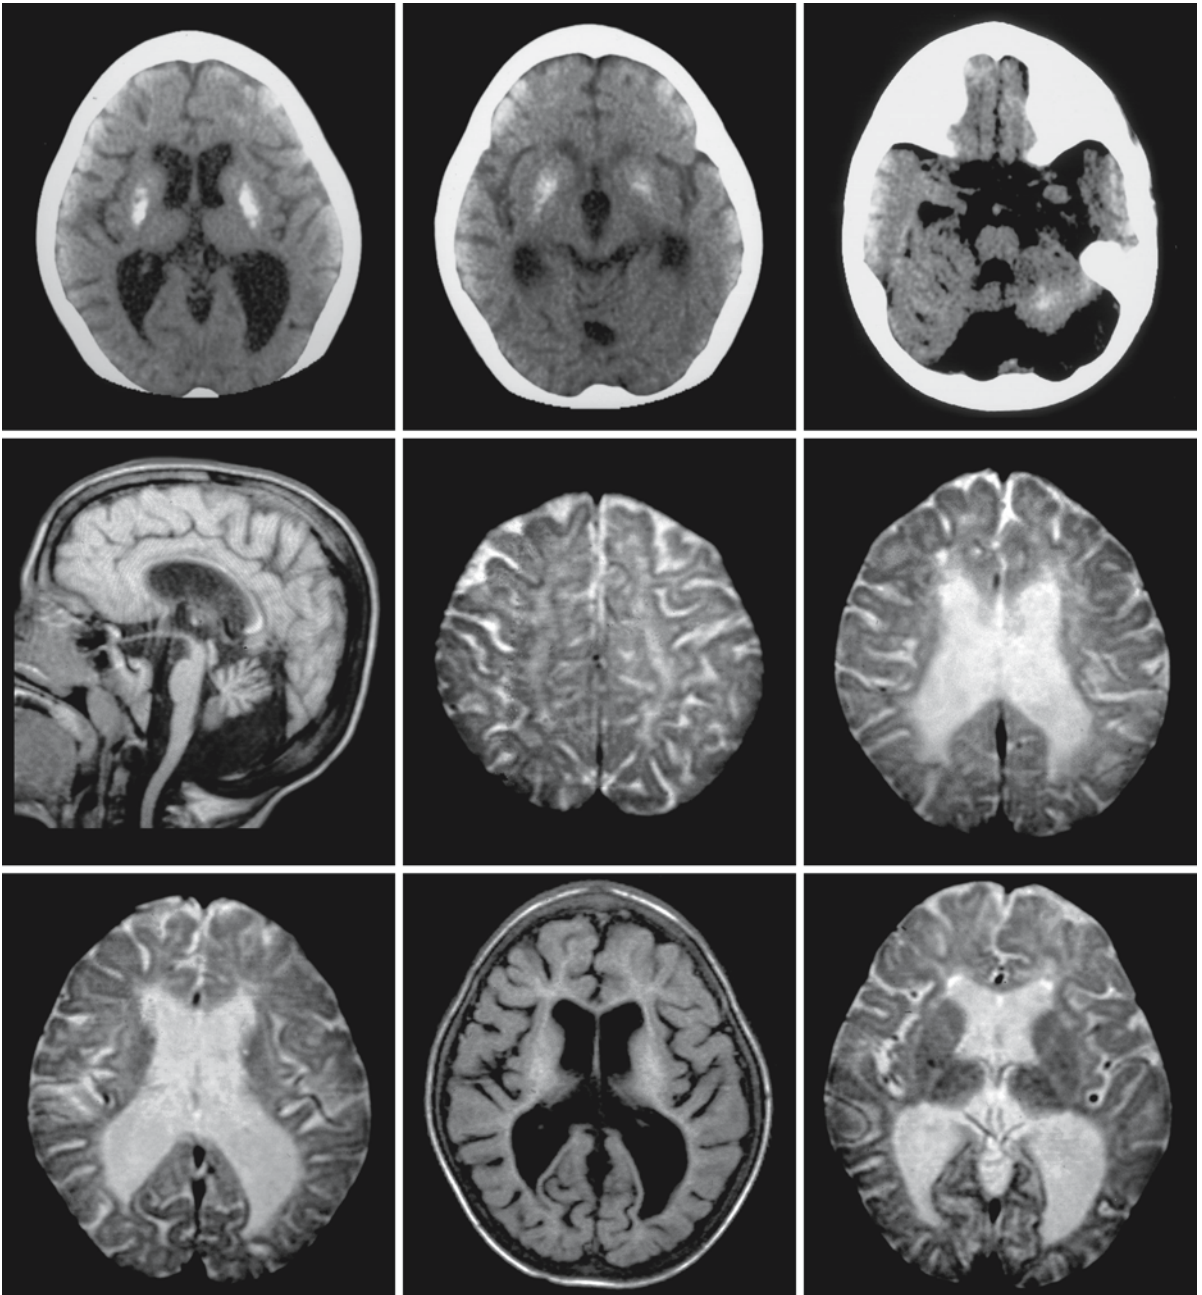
A 6-year-old girl with CS type I. CT scans through the posterior fossa and the lateral ventricles show calcifications in the dentate nucleus and the basal ganglia. The T_2 -weighted MR images reveal white matter hypomyelination and atrophy.
